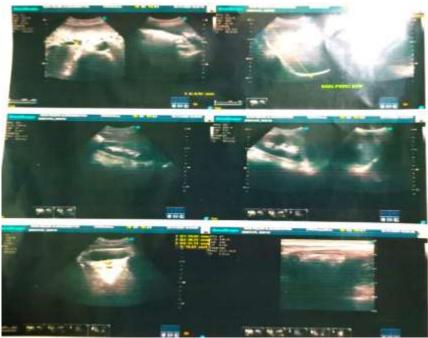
Ultrasonography of patient showing well defined hypoechoic lesion in lower esophagus.
